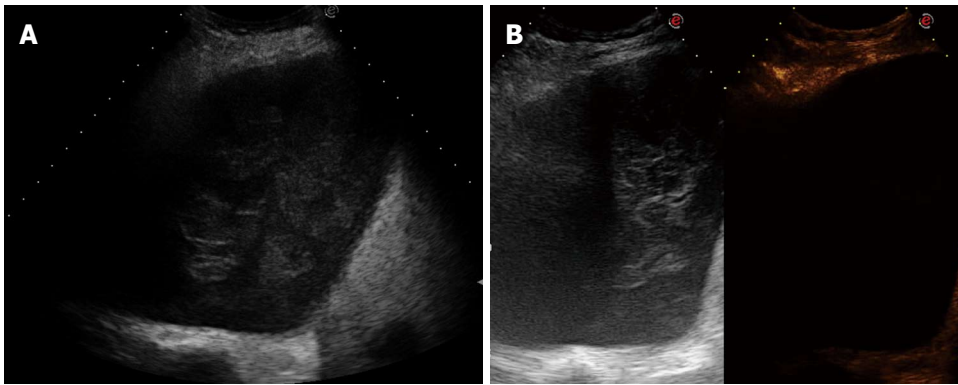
Absence of arterial enhancement. A: transverse sonogram of the right chest wall in the sixth posterior intercostal space showing an inhomogeneous mass in the pleural space; B: transverse contrast-enhanced sonogram of the mass showing complete absence of enhancement in the arterial phase. Final diagnosis was haemothorax with a large clot.
